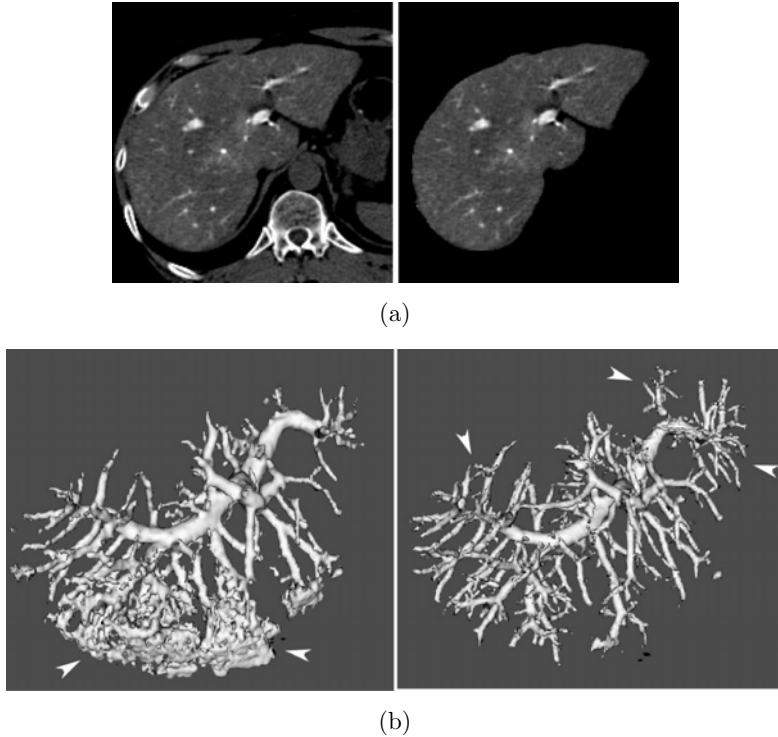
Liver vessel (portal vein) segmentation from abdominal CT images. (a) Original cross-sectional images (left) and segmented liver region (right). (b) Original (left) and line-filtered (right) surface-rendered images.
